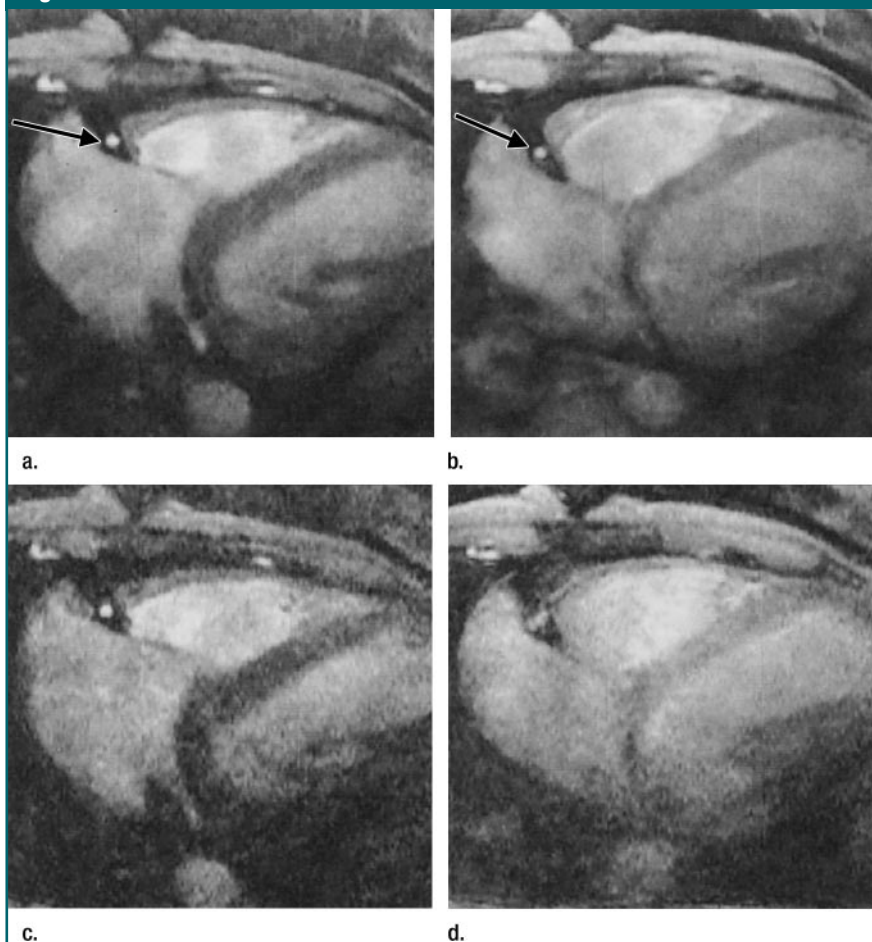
(a–d) Magnitude MR images from phase-velocity mapping study of right coronary artery (arrow) in a healthy volunteer during (a, c) mid-diastole (when the heart is relatively stationary) and (b, d) early systole (during rapid cardiac motion). Images were acquired with (a, b) retrospective respiratory gating with an over-imaging factor of eight and acquisition window of 32 msec and (c, d) during breath holding with acquisition window of 126 msec. In diastole, retrospective respiratory-gated and breath-hold studies both result in good quality images. In systole, rapid cardiac motion and long acquisition window result in considerable motion blurring of the artery. (Adapted and reprinted, with permission, from reference 75.)
